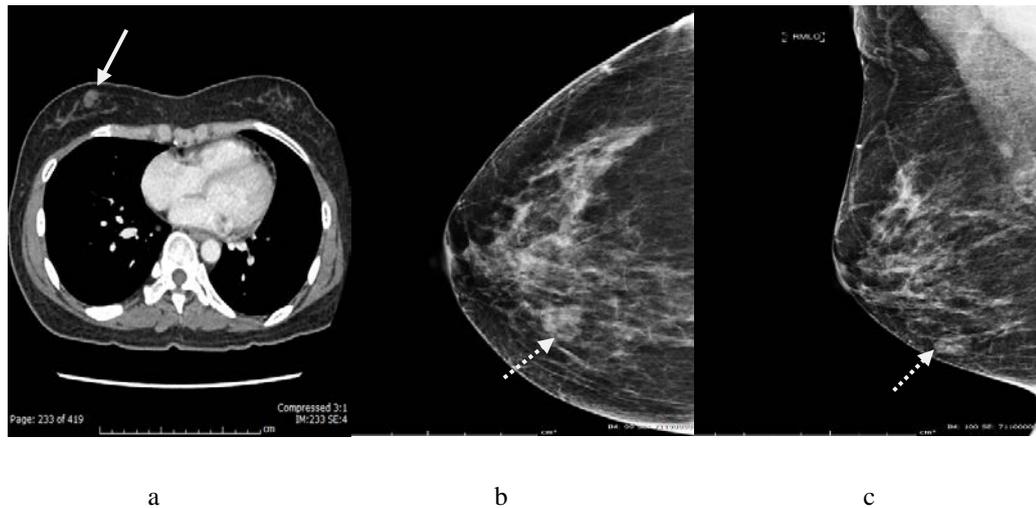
(a) Axial contrast enhanced CT showed right breast mass with enhancement (arrow), interpreted as BIRADS 4. No obvious internal fat or capsule was observed.
